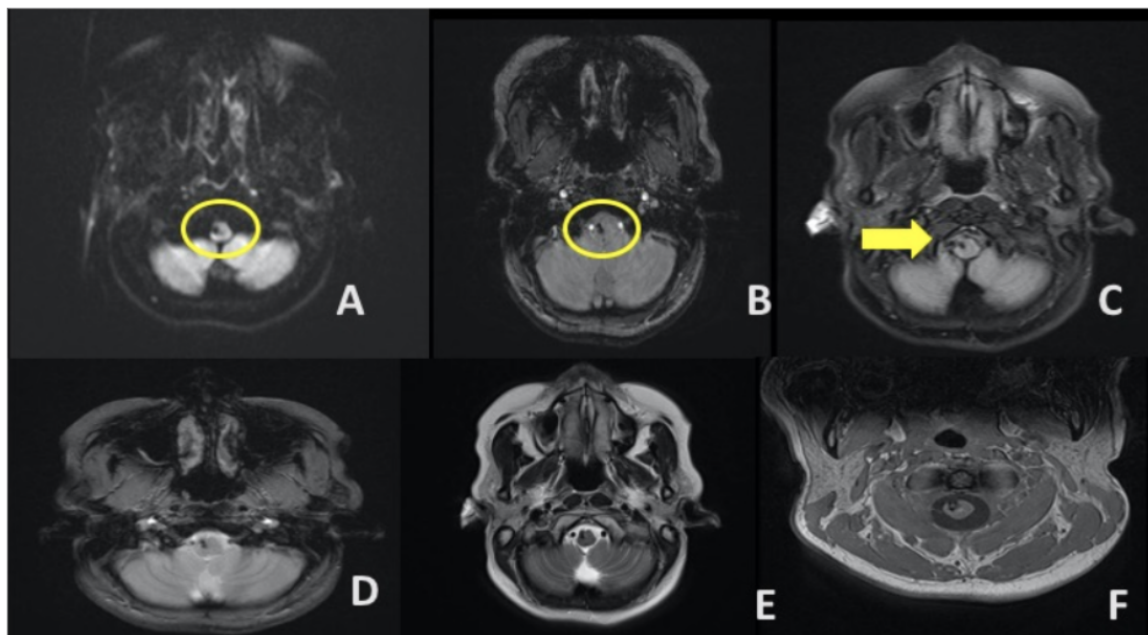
Follow-up study after 3 months: MRI Cranial Axial DWI Image (A) GRE (B) still showed a susceptibility signal in the cervicomedullary junction (CMJ). T2 Axial Flair Image (C), now shows a hypointense lesion in the caudal medulla. Axial T2 TRA (E) and T1 VIBE TRA (F).
